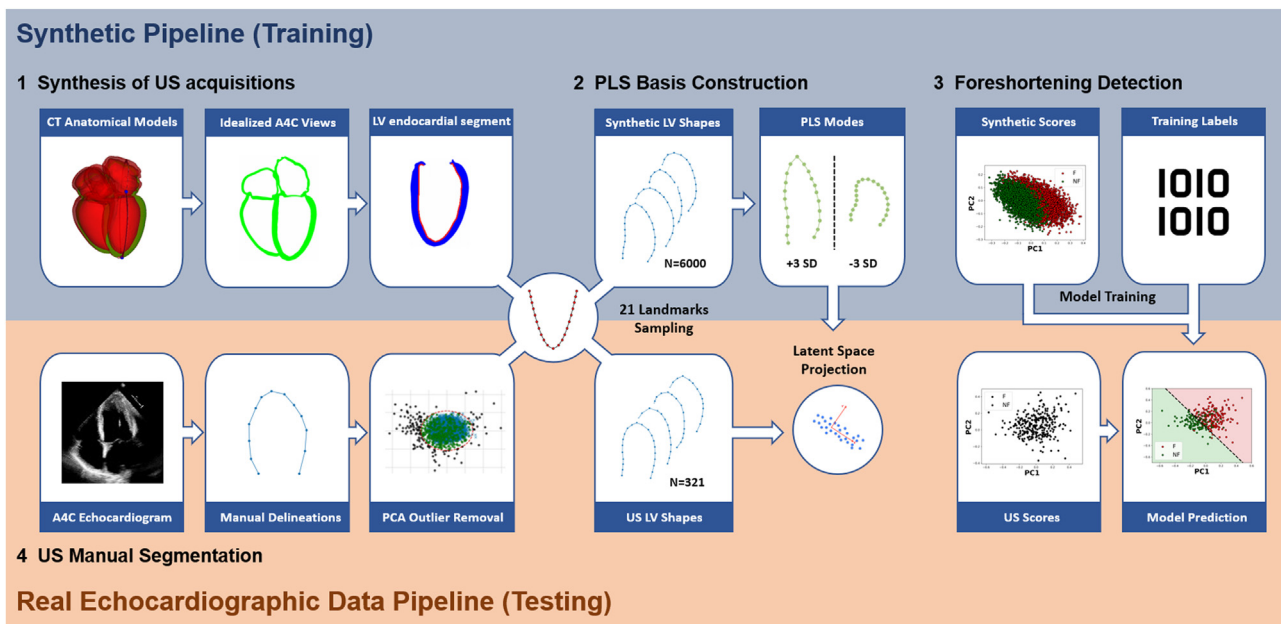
Overview of the proposed pipeline for extraction of the anatomical variation related to foreshortening and to use the learned features for foreshortening detection in real ultrasound images. A4C, apical four-chamber; CT, computed tomography; F, foreshortened; LV, left ventricle; N, number of LV contours; NF, non-foreshortened; PCA, principal components analysis; PLS, partial least squares; SD, standard deviation; US, ultrasound.
